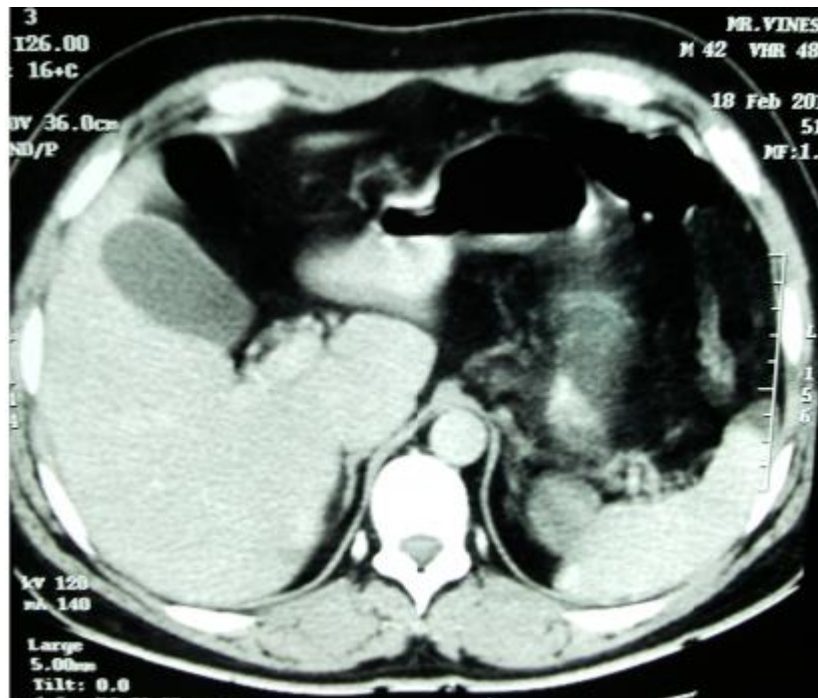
Computerized tomography (CT) imaging of abdomen showing mild hepatomegaly (15.8cm). No evidence of any intrahepatic biliary radical dilatation (IHBRD) noted. Gall bladder is distended with normal wall thickening
